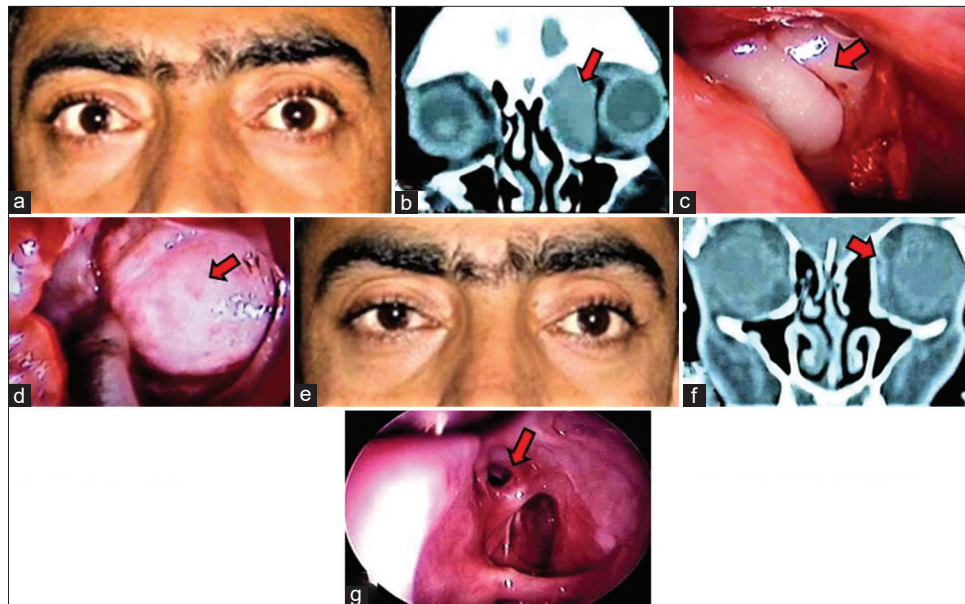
(a) Preoperative photograph showing proptosis of the left eye, (b) Computed tomography scan showing lesion with displaced eyeball, (c) Mucocoele exposed and drained, (d) Exposed eyeball seen due to erosion of medial wall of orbit, (e) Postoperative photograph showing resolution of proptosis, (f) Eyeball in normal position, (g) Patent frontal sinus ostium at 12-month follow-up
